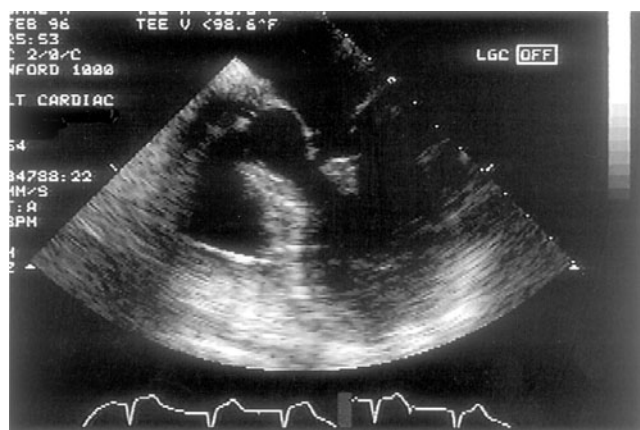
Echocardiogram (two-chamber view) of a patient with mitral regurgitation owing to ruptured papillary muscle.
